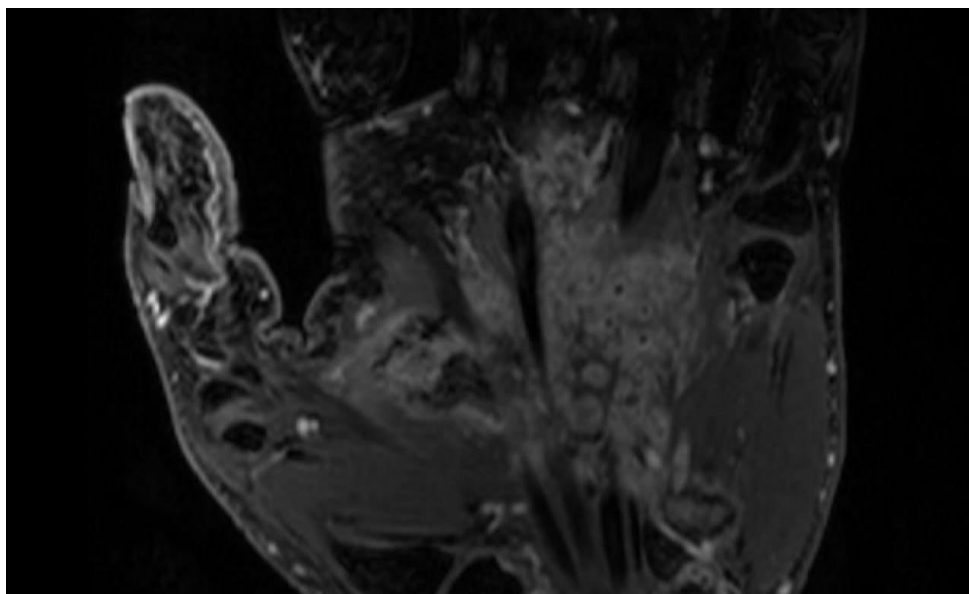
Coronal T1-weighted fat-suppressed post-contrast MRI image of the hand showing multiple enhancing nodular and serpiginous lesions involving the subcutaneous tissues and intermuscular planes, with associated surrounding soft tissue enhancement, suggestive of mycetoma
